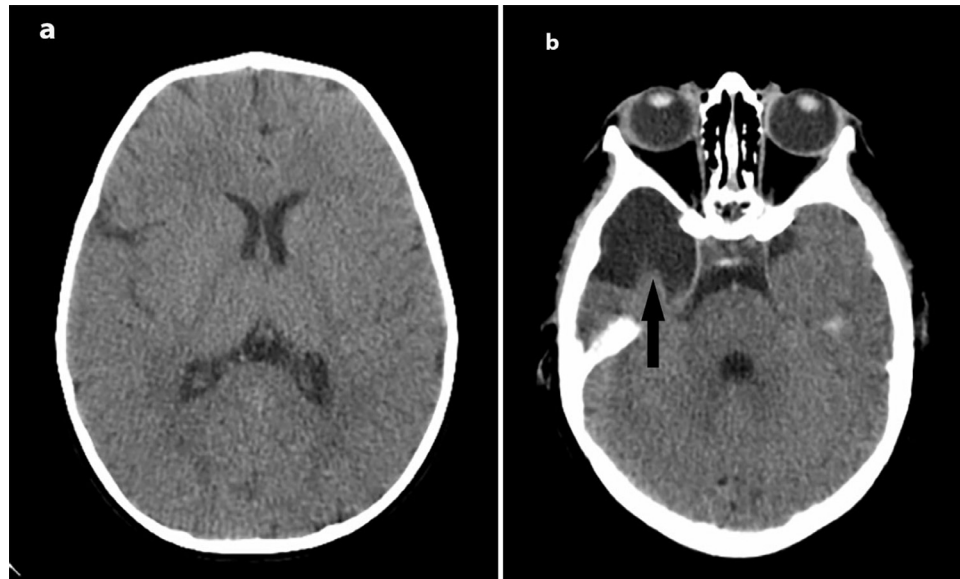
(a, b): Axial CT images at 8 months of age. An arachnoid cyst is seen along the right anterior temporal lobe (black arrow). The sulci, fissures, and cisterna are unremarkable. The ventricular system demonstrates no dilatation, distortion, or displacement. There is no displacement of the midline structures. No subdural collections are present in this study.
